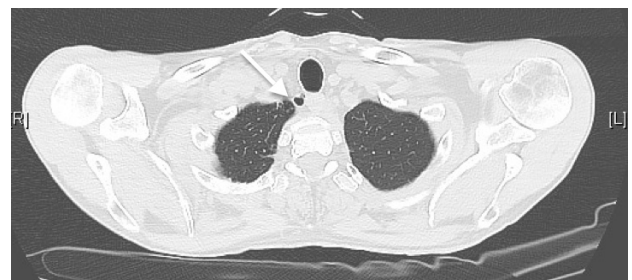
Tracheal Diverticulum: CT assial scan showing a paratracheal air collection (arrow).
